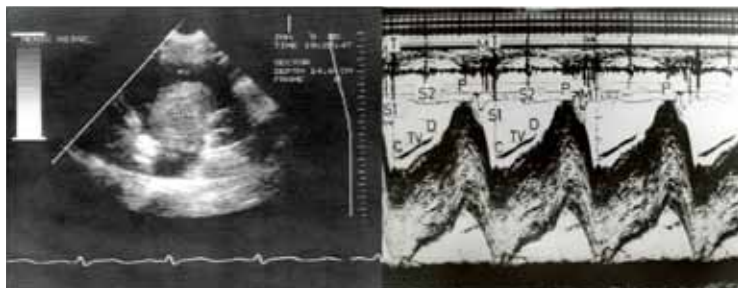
RIGHT ATRIAL MYXOMA WITH LATE DIASTOLIC TUMOR TUMOR "PLOP"- LEFT PARASTERNAL SHORT AXIS VIEW. LEFT panel-two dimensional view, RIGHT panel-echophonocardiographic recording. MY(TU)-myxoma;RA-right atrium;RV-right ventricle;S1-first sound;S2-second sound;P-tumor plop;M-mitral component of the first sound;T-tricuspid component. MY-miksom;RA-right atrium;RV-right ventricle
